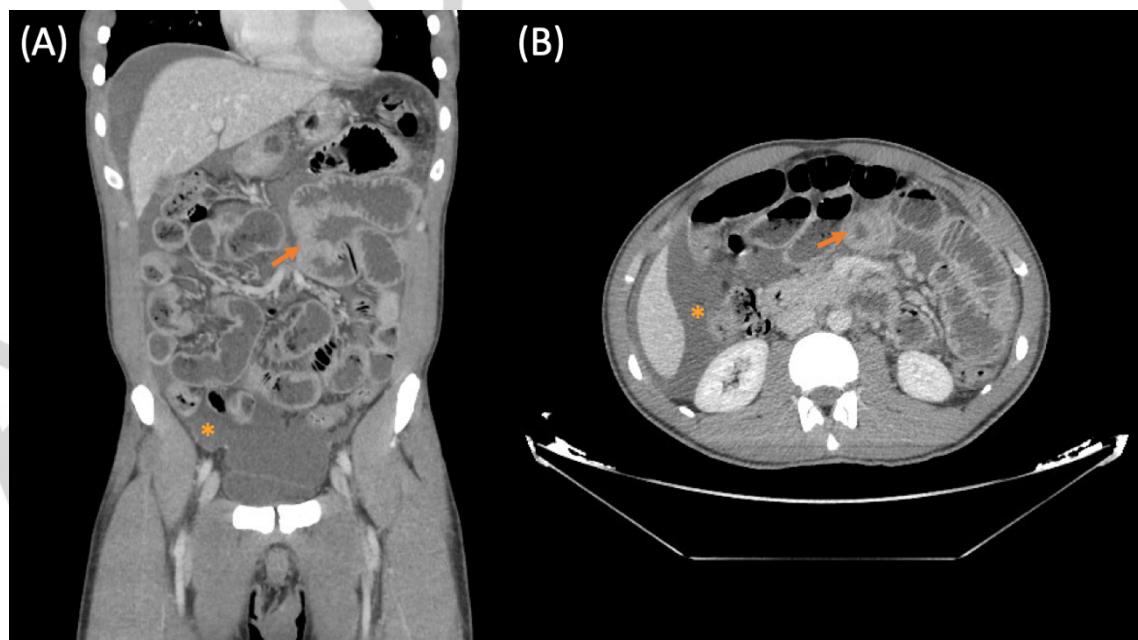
Abdominal CT scan demonstrating diffuse jejunal wall thickening (arrow) with associated ascites (asterisk) on coronal (A) and axial (B) views.
